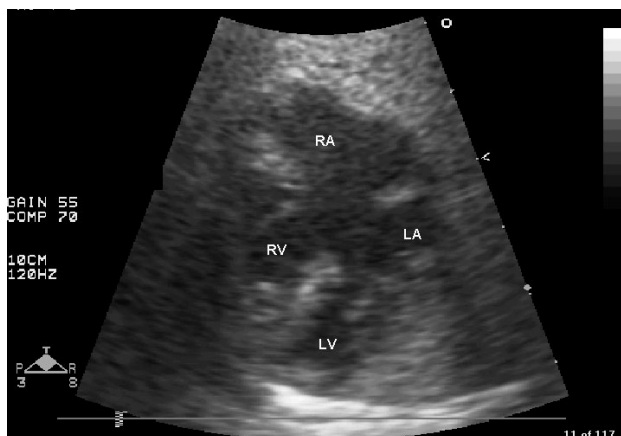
The apical four-chamber view of the heart in diastole showing a complete atrioventricular septal defect seen as a large defect at the crux of the heart
